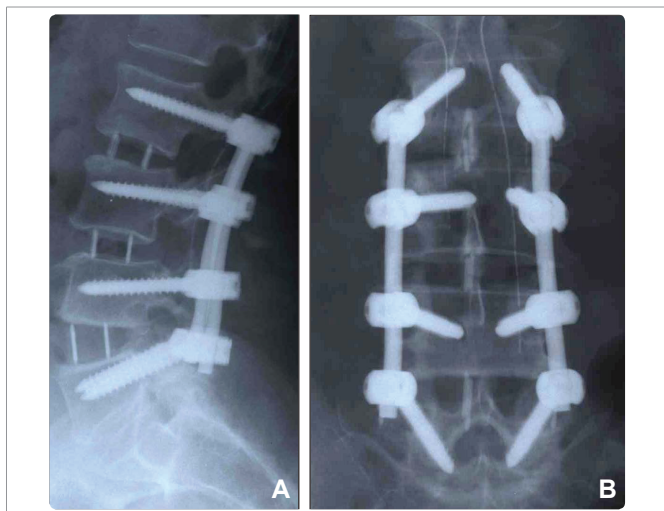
Postoperative X-rays of the lumbar spine of the same patient demonstrating reposition of spondylolisthesis L3/4, straightening of scoliosis, and restoration of height of intervertebral space in the L2/3, L3/4, and L4/5 levels. Note the restored sagittal balance of the lumbar spine with normal lordosis.
